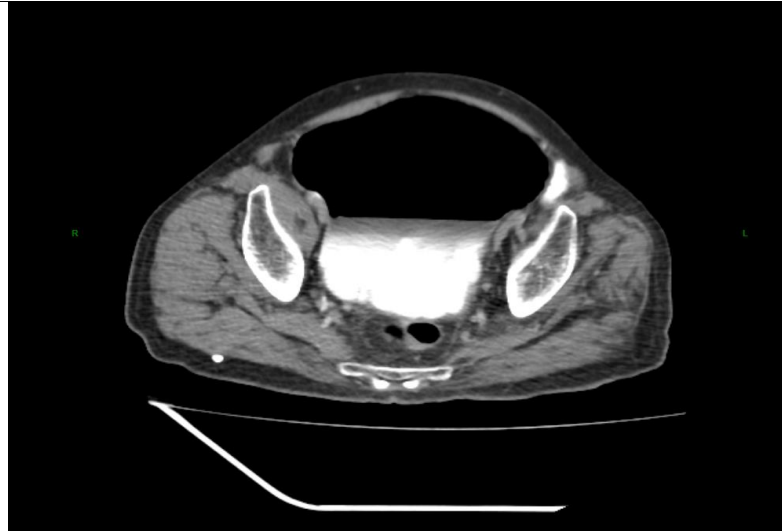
DELAYED AXIAL CUT OF CONTRAST ENHANCED CT SCAN SHOWING PNEUMOBLADDER
